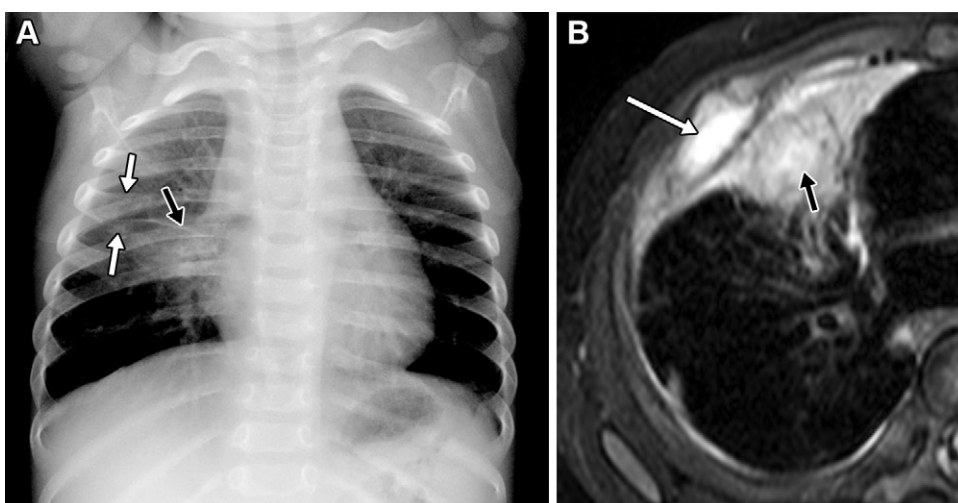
Osteomyelitis of a rib associated with pneumonia in a 7-month-old girl. (A) Frontal chest radiograph shows expansion of the anterior end of the right fourth rib (white arrows) with adjacent airspace opacification and thickening of the interlobar fissure (black arrow). (B) Axial postcontrast fat-suppressed T1-weighted MR image shows abnormal bone marrow enhancement (white arrow) associated with lung consolidation (black arrow).
